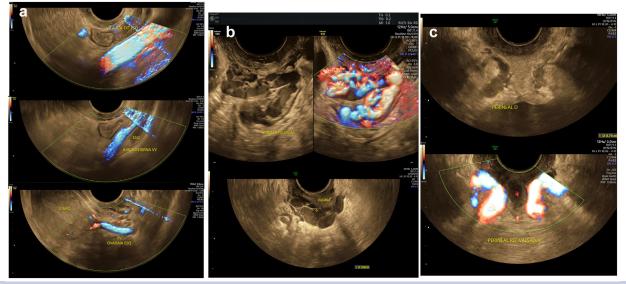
A, External iliac, internal iliac, and left gonadal veins. B, Dilated and insufficient peri-uterine and peri-vaginal plexuses. C, Perineal escape point on transvaginal ultrasound examination. Authors archive.
